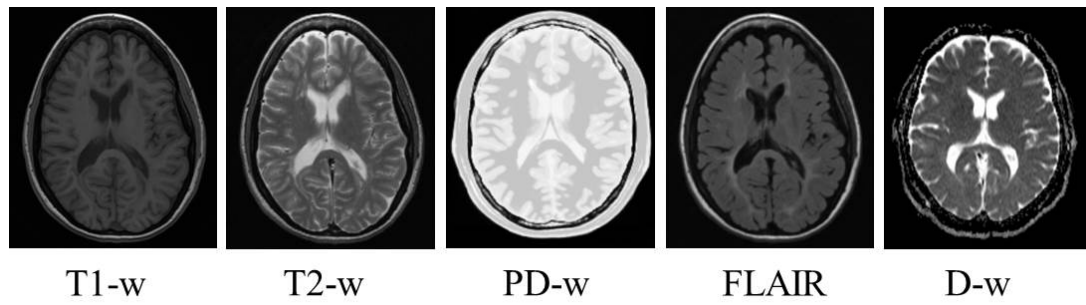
Example of brain MR images of various sequences. T1-w, T2-w and FLAIR images are from MICCAI 2008 MS lesion segmentation challenge [253]; PD-w image is from [46]; D-w image with ADC mapping is from [88].
